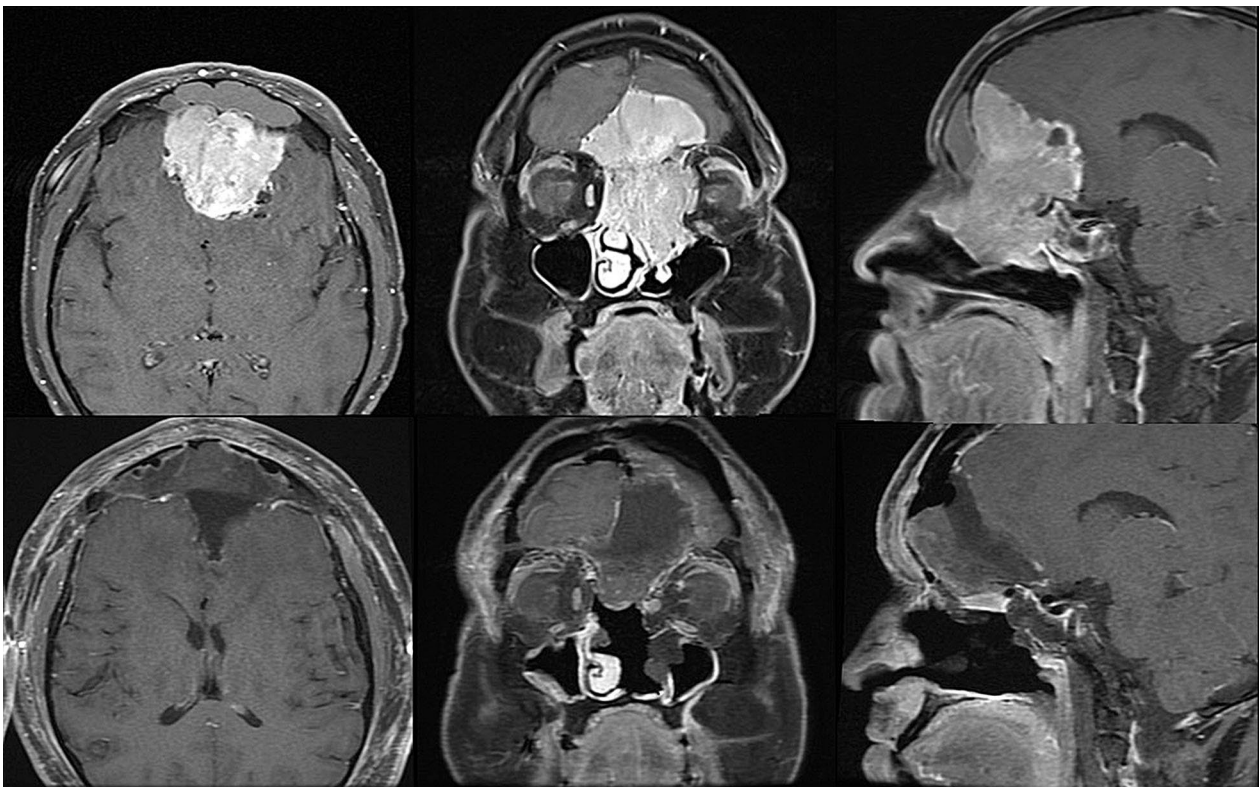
Axial (top left), coronal (top middle), and sagittal (top right) T1 post-contrast magnetic resonance imaging of a 36-year-old patient with a Hyams grade 2, Kadish-Morita stage C olfactory neuroblastoma with brain and orbital invasion. Cranio-endoscopic resection resulted in gross total resection with negative margins (bottom). Of
